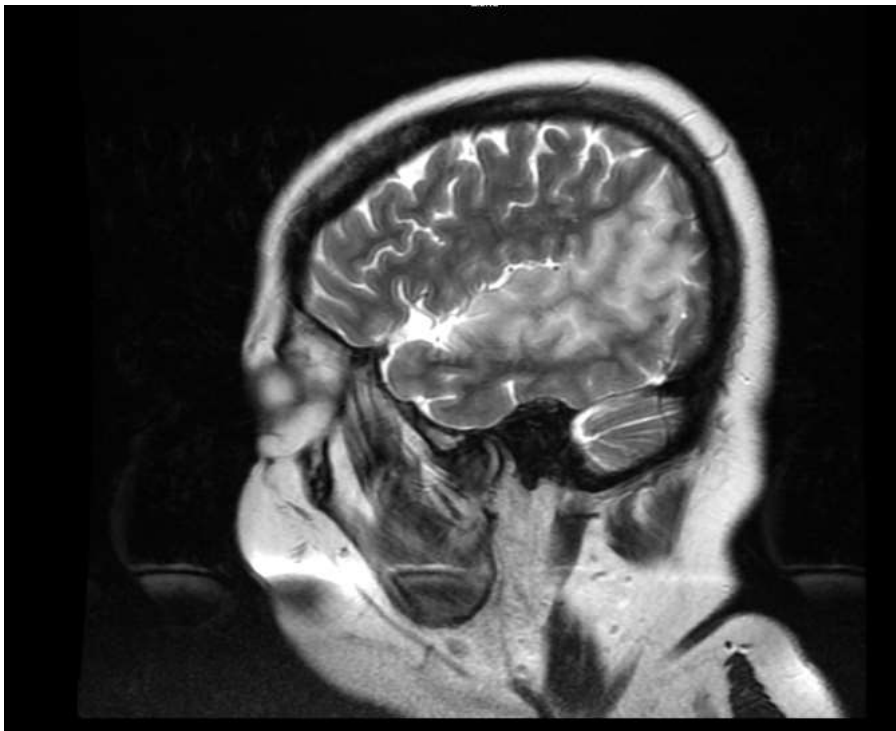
CT of the head (T2 FRFSE; fast-recovery fast spin-echo) – within the temporal lobe hyperintensive areas with diffusion restriction are visible [authors' material]
